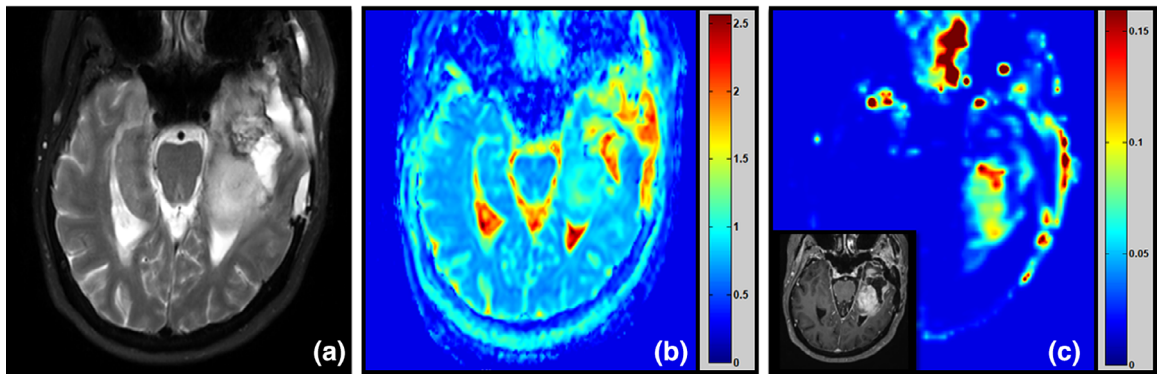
Representative pretreatment MR images of a patient with grade IV brain tumor (65 years, female). (a) T_2 -weighted image. (b) $ADC \times 10^{-3}$ (mm^2/s) map generated using 3 b -values ($b = 0, 100, 1000 \text{ s}/\text{mm}^2$). (c) K^{trans} (min^{-1}) map generated from DCE data with insert of T_1 -weighted gadolinium contrast image. (Images contributed by Thomas Chenevert, University of Michigan.)
